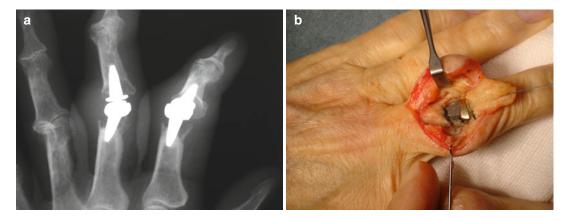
(a, b) Radiographs and operative photographs showing osteolysis and metallosis in failed LPM implants
